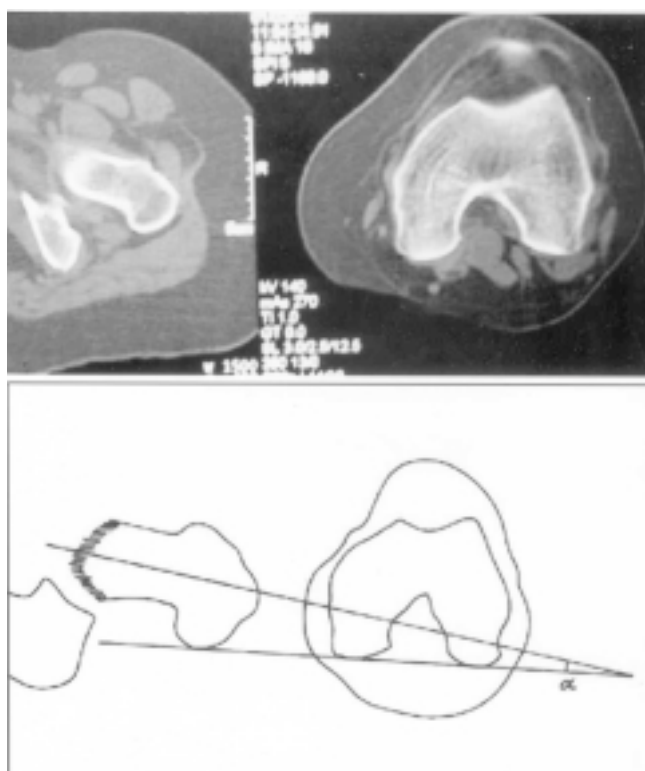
Showing the estimation of femoral neck anteversion by the CT method. It (α) is the angle between the neck and condylar axis.
